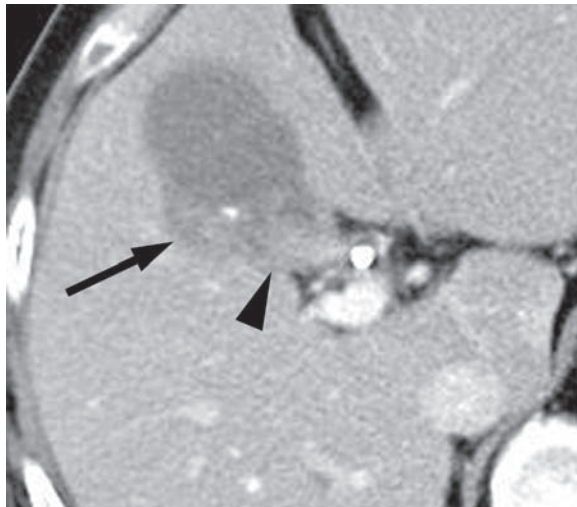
Direct invasion of the liver by gallbladder cancer in a 66-year-old woman. Contrast-enhanced CT scan shows a subcapsular hypoattenuating mass (arrow) near the gallbladder, which contains a gallstone and a mass (arrowhead).
